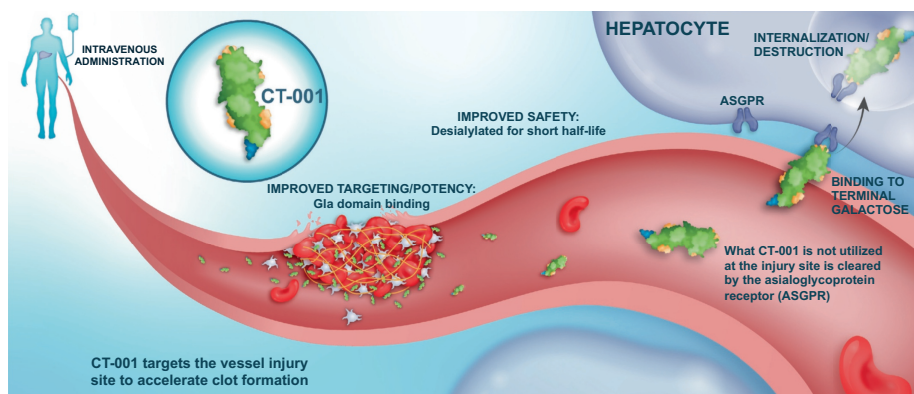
Mechanism-of-action of CT-001. This uniquely engineered, recombinant coagulation factor VIIa (rFVIIa) is administered intravenously. Gamma-carboxyglutamic acid (Gla)-domain amino-acid substitutions improve bleeding-site targeting and potency, accelerating clot formation. Unused CT-001 molecules are rapidly cleared from circulation via the recognition of exposed galactose residues by asialoglycoprotein receptors (ASGPRs) expressed on hepatocytes. CT-001’s enhanced efficacy and safety have been demonstrated in preclinical studies^{1,2}.
